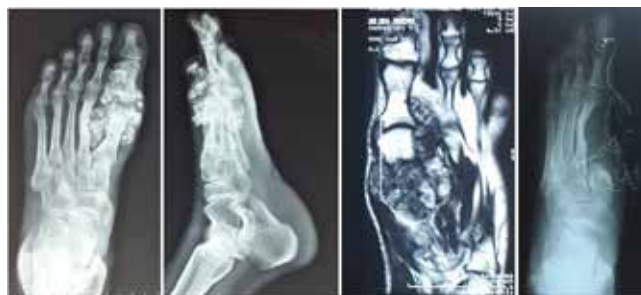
case no.1: chondrosarcoma around the first MTP joint, in the radiograph and MRI images, aggressive expansile tumoral lesions stemmed from the first metacarpal bone with the apparent extension to the soft tissue and having chondroid matrix is presented. a) ap x-ray b) lateral x-ray c) coronal + axial MRI section d) postoperative ap x-ray
